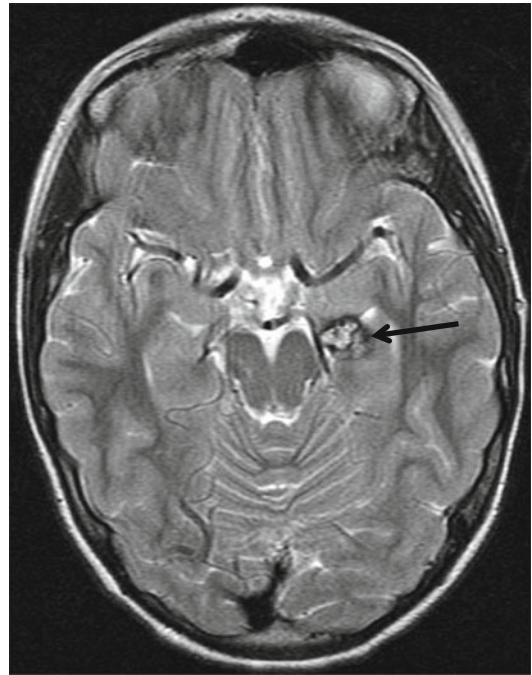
MRI of cavernous malformation
